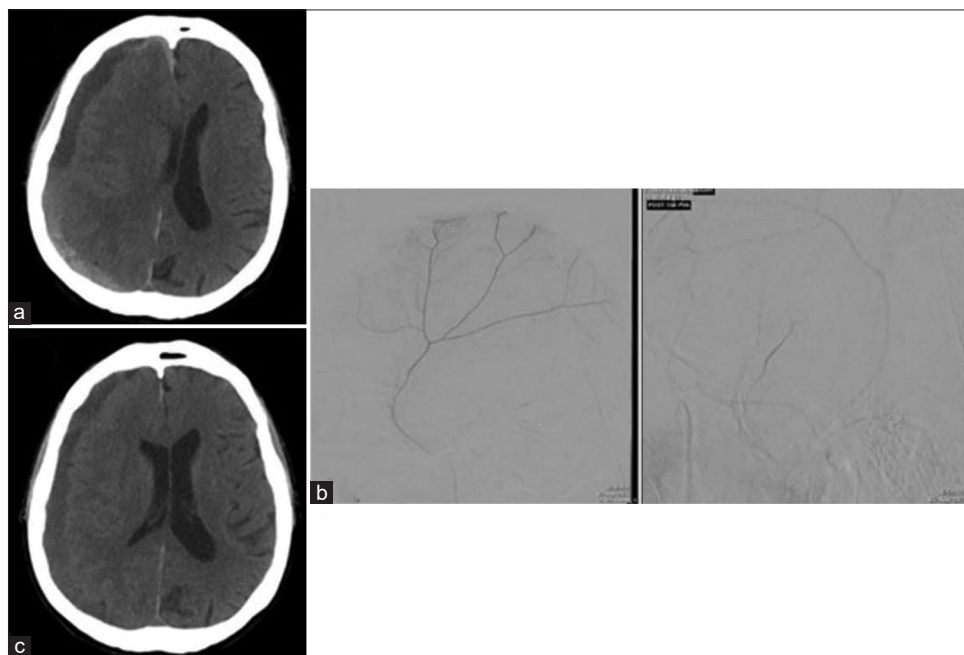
Evolution of subdural hematoma (SDH) from presentation to 45 days later via head computed tomography (CT). (a) Head CT at initial presentation revealed a right-sided, mixed density 12 mm SDH with 12 mm midline shift to the left. (b) Cerebral angiogram visualizing middle meningeal artery. (c) Repeat head CT on hospital day 17 showing stable right SDH with resolving midline shift (5 mm to left).
